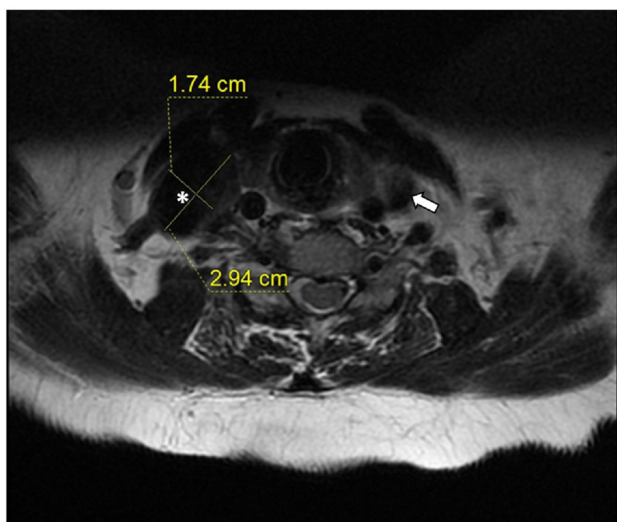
Axial MRI, showing dilated right IJV (white asterisk) measuring 2.9 x 1.7 cm in maximum diameter as compared to normal left IJV (white arrow) on T2-weighted image
